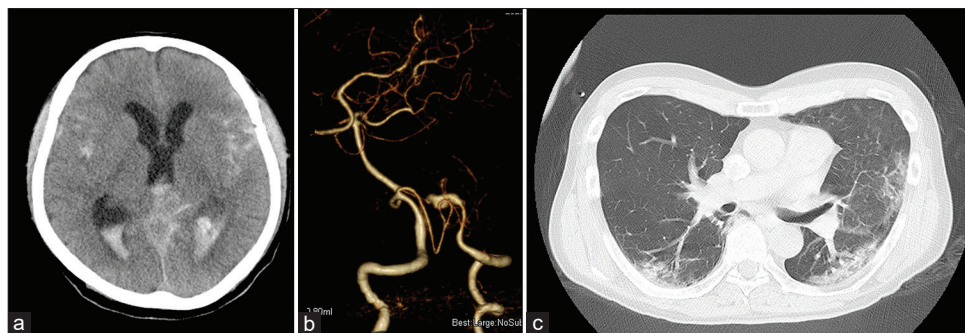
Computed tomography (CT) and three-dimensional CT angiogram on admission after COVID-19 onset day 3 (a) diffuse subarachnoid hemorrhage with intraventricular hemorrhage and hydrocephalus. (b) Pearls and strings are seen in the left vertebral artery. (c) Chest CT shows multiple frosted shadows are seen in the bilateral lung fields.
